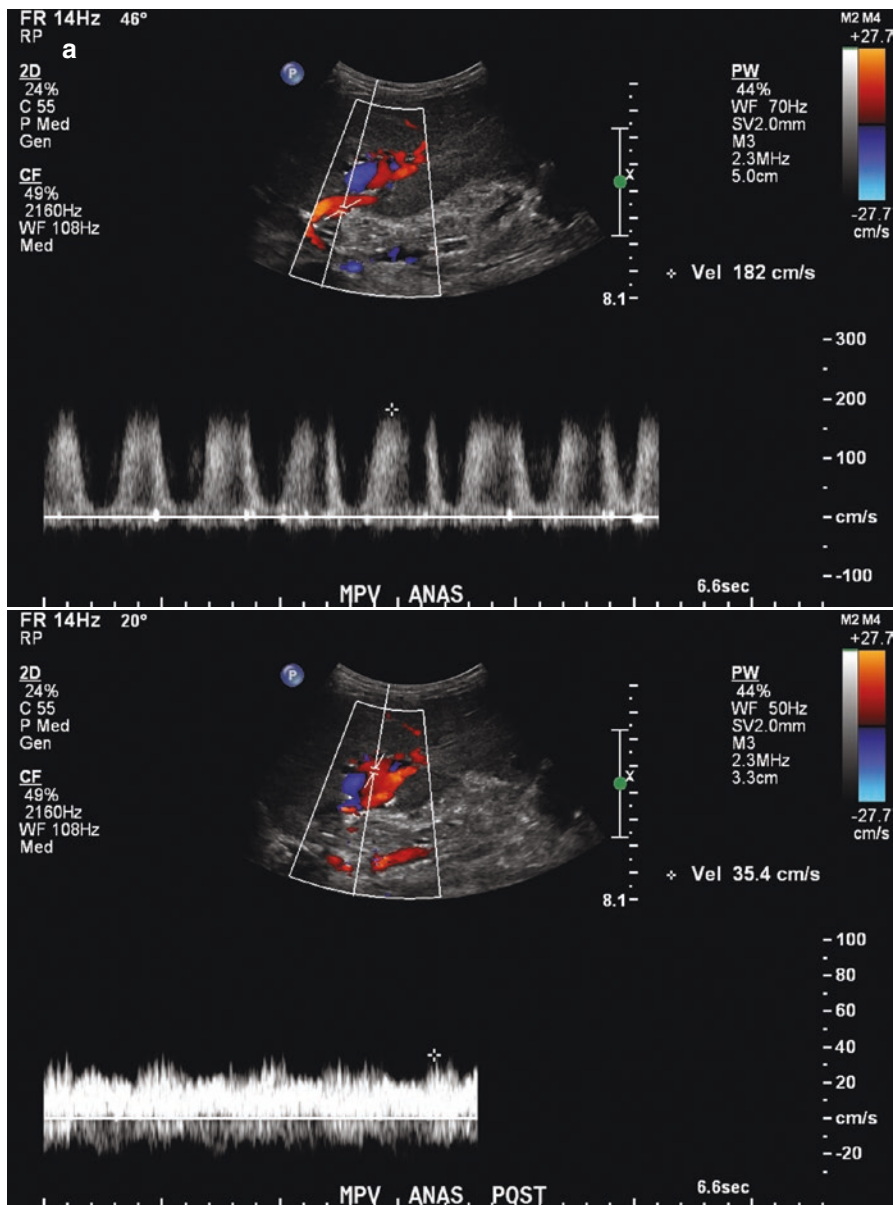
Portal vein stenosis: (a) ultrasound demonstrates elevated velocities at the portal vein anastomosis. (b) Digital subtraction venography (DSV) of the left portal vein demonstrates stenosis of the main portal vein at the anastomosis (arrow). (c) Balloon angioplasty of the portal vein stenosis. (d) Post-venoplasty DSV demonstrates marked improvement of the stenosis
